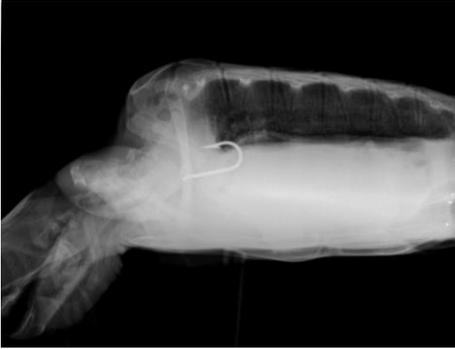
X-ray dorsal-ventral projection showing a hook into the oesophagus wall.
